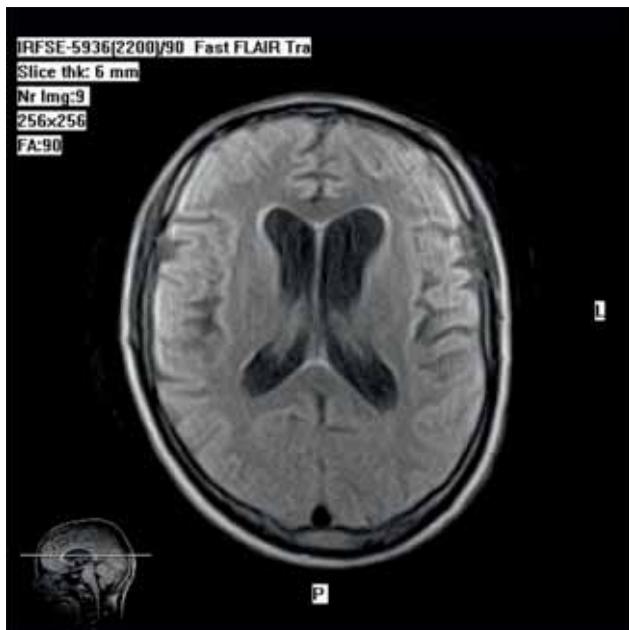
Axial FLAIR MRI suggesting moderate normal pressure hydrocephalus
